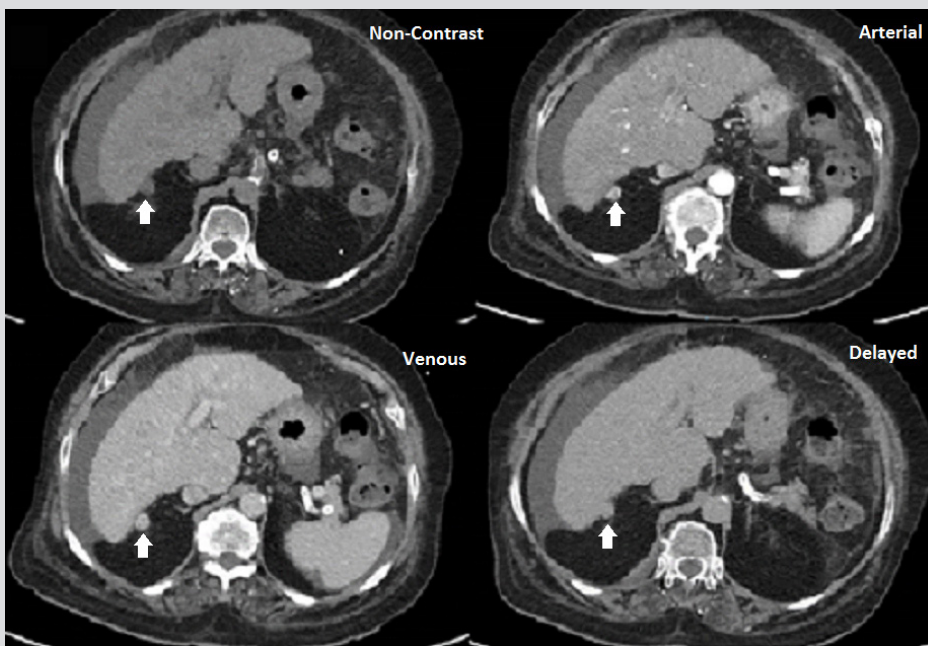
Quadriphasic contrast-enhanced CT scan images, showing the exophytic lesion (white arrows)
